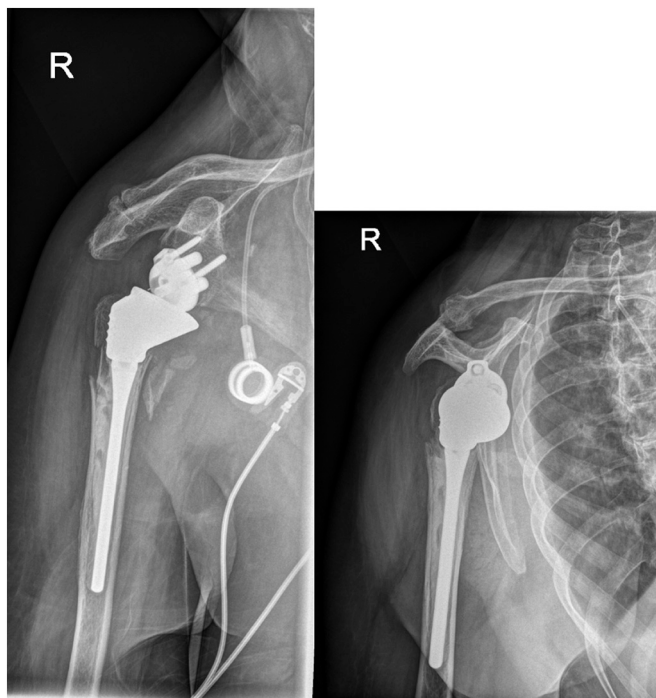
X-ray after implantation of a reverse shoulder prosthesis.
